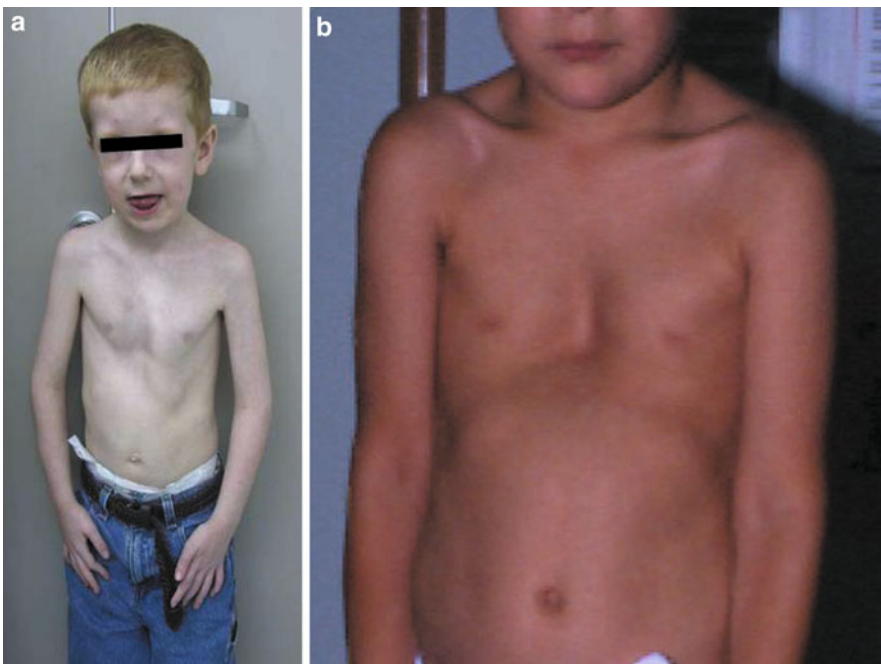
(a, b) Two children with Marfan syndrome showing pectus and arachnodactyly. The first patient had dural ectasia detected by MRI. The second patient had aortic root dilatation and mitral valve prolapse
